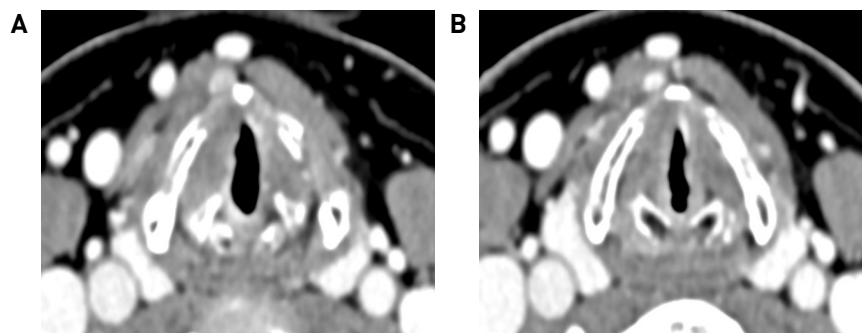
(A, B) Laryngeal CT taken after the laryngomicrosurgery. (A) Mucosal surface irregularity and enhancing wall thickening in both vocal cords and subglottic space are shown. (B) Narrowing of glottic lumen can be observed.
